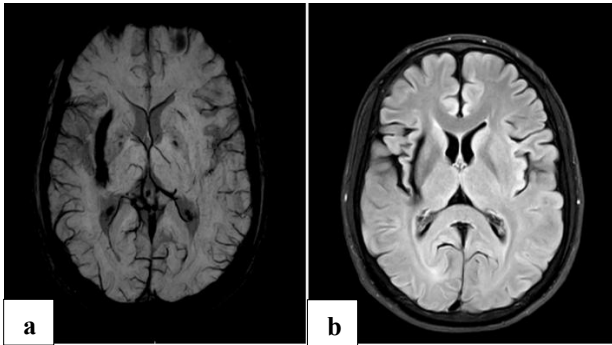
MRI brain showing (a) blooming hypointensity in SWI image, and (b) evidence of gliosis and volume loss in FLAIR image in right capsule ganglionic area suggesting a sequelae of old intracerebral hemorrhage.
